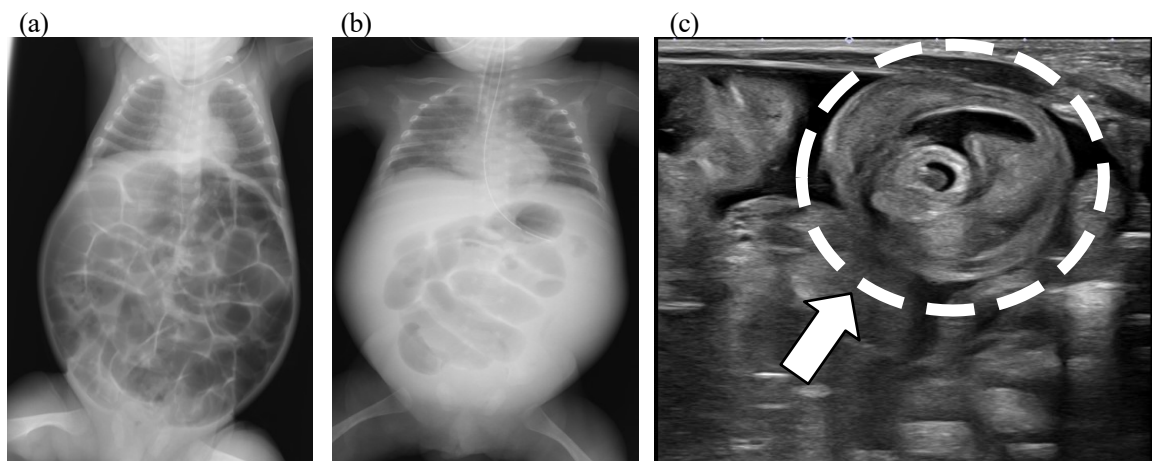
(a) Simple x-ray at DOL 84. During sudden worsening of abdominal distention
